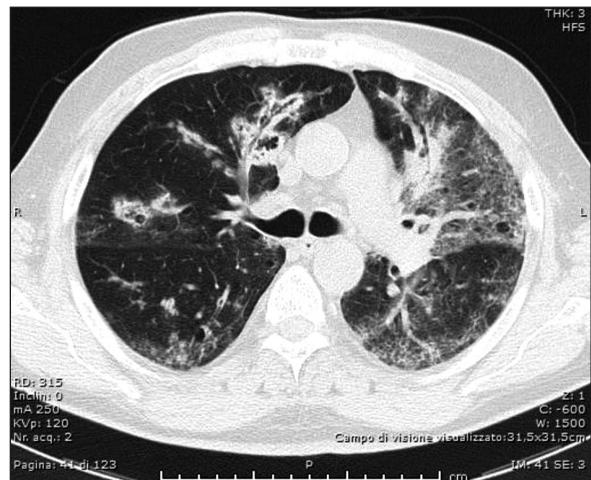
Thoracic CT: consolidations and tree-in-bud sign.
